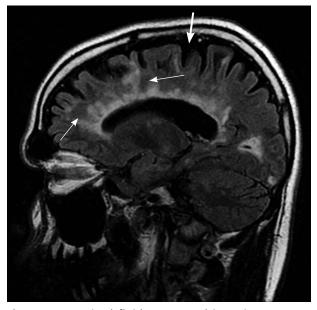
A sagittal fluid attenuated inversion recovery (FLAIR) image shows multiple white matter lesions involving the corpus callosum, radiating from the lateral ventricles (thin arrows). These are known as Dawson fingers and are highly correlated with multiple sclerosis. Additionally, cerebral atrophy, which is commonly found in multiple sclerosis, is present (thick arrow).
